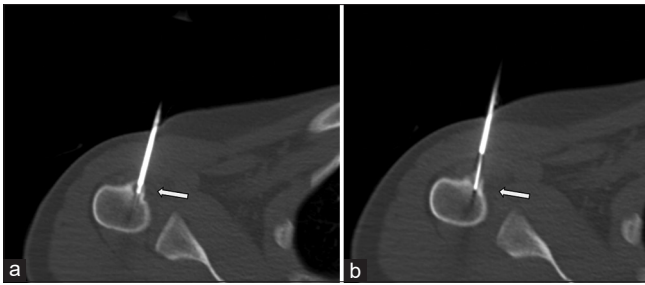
(a and b) Axial CT images of the right shoulder taken during the RFA procedure demonstrate biopsy needle within the nidus (arrow in a). The second image shows position of the RFA probe within the nidus (arrow in b). RFA – Radiofrequency ablation; CT – Computed tomography
